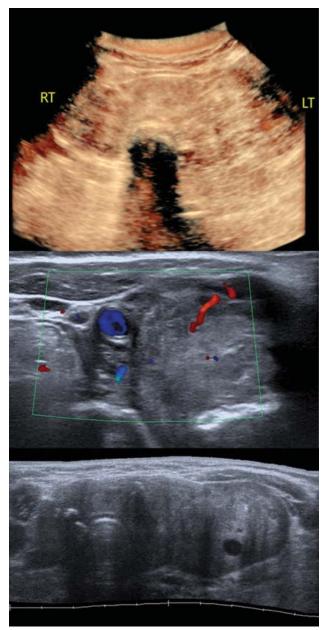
Amiodarone induced Type 1 thyrotoxicosis. A known patient of ventricular arrhythmia treated with Amiodarone. He presented with pain in neck and clinical symptoms of thyrotoxicosis. Ultrasound shows enlarged thyroid with inhomogeneous texture and hypoechoic areas. On color flow imaging, multiple vessels are seen feeding the thyroid gland and moderate increased vascularity is seen in both the thyroid lobes suggestive of Amiodarone-induced thyrotoxicosis.
